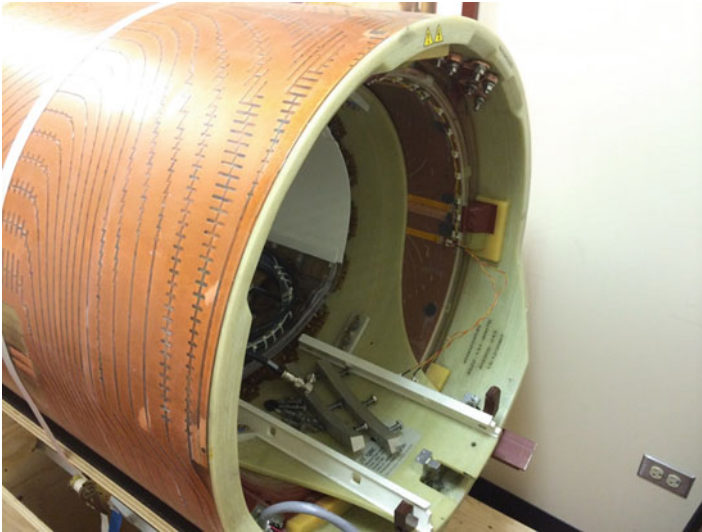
Gradient system of an MRI system with x -, y -, and z -gradient coils embedded in epoxy. The gradient coils are used to localize the MR signal from a specific location in the human body
